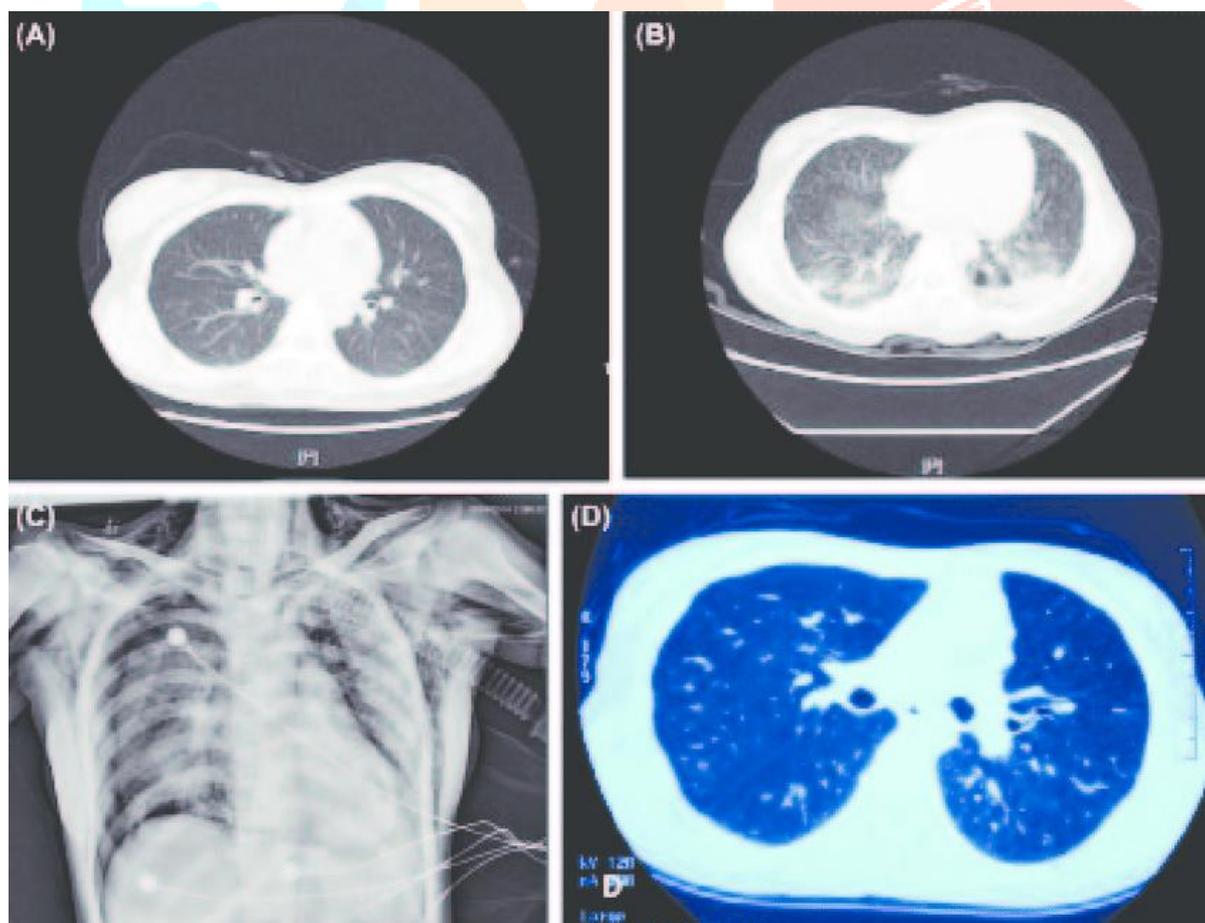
Imaging (A) The 5th day after paraquat poisoning: increased interstitial markings in bilateral lungs. (B) The 21th day after paraquat poisoning: multiple exudations in bilateral lungs, with an expansion of the pulmonary consolidation. (C) The 34th day after paraquat poisoning: pneumothorax of both lungs. (D) HRCT at the 1-year follow-up after lung transplantation.
